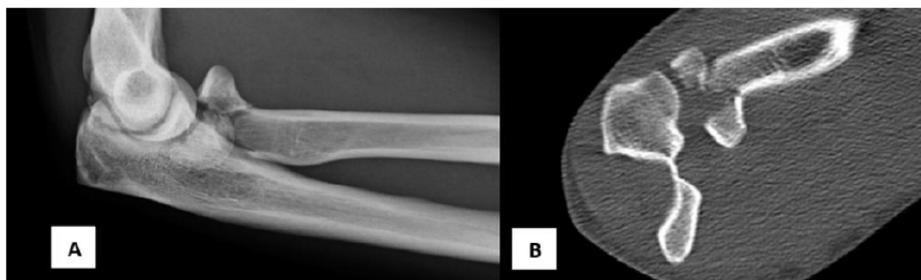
A, Latero-lateral projection x-ray of the left elbow showing the type III radial head fracture according to Mason's classification. B, CT coronal section showing a comminuted fracture of the radial head.
